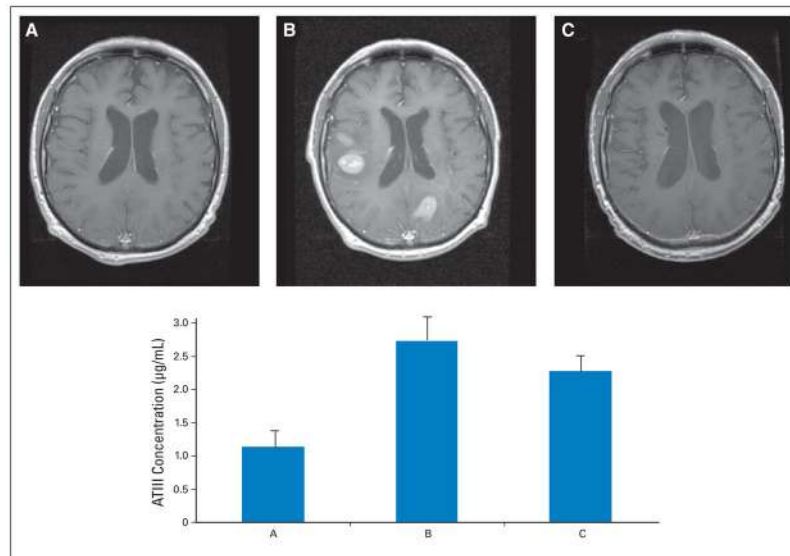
CSF antithrombin III (ATIII) concentration reflects persistent disease in patient with refractory CNS lymphoma (A) Remission. (B) Relapse of CNS lymphoma; remission was later achieved after brain irradiation. (C) Two months after irradiation, the patient exhibited new cranial nerve deficits and gait instability; magnetic resonance imaging of brain and spine as well as CSF cytology were negative. Columns, mean; bars, standard deviation.
